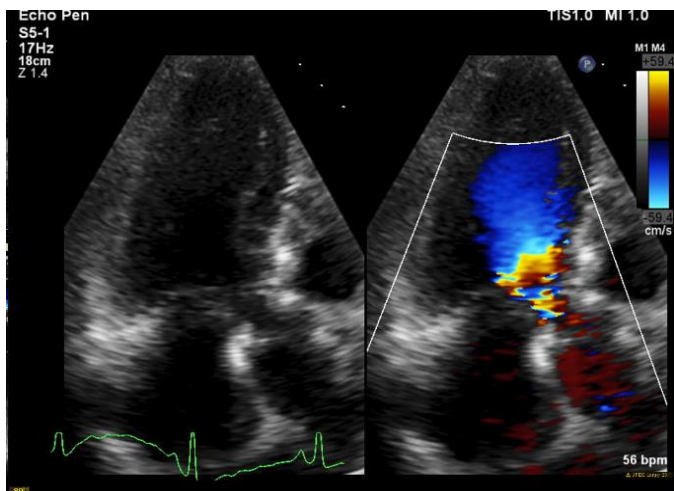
Color Doppler comparison images in apical 3-chamber view on transthoracic echocardiogram. Flow acceleration with aliasing is visible in the left ventricular outflow tract, well before the aortic valve, suggesting pathology in the subaortic valve region.
